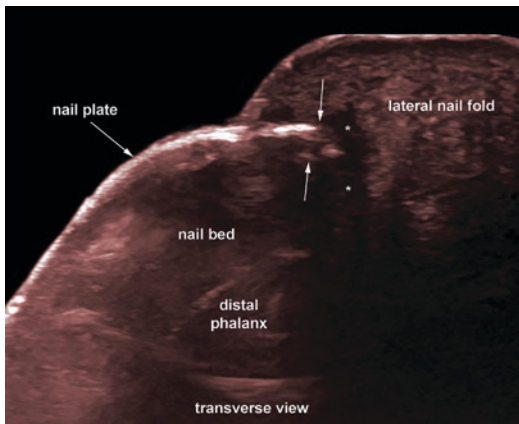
Onychocryptosis. Ultrasound image (18 MHz; transverse view; colored; right big toe) shows hyperechoic and irregular fragment (vertical arrows pointing up and down) embedded in the lateral nail fold. Notice the hypoechoic band (*) in the dermis of the lateral nail fold that corresponds to inflammation
